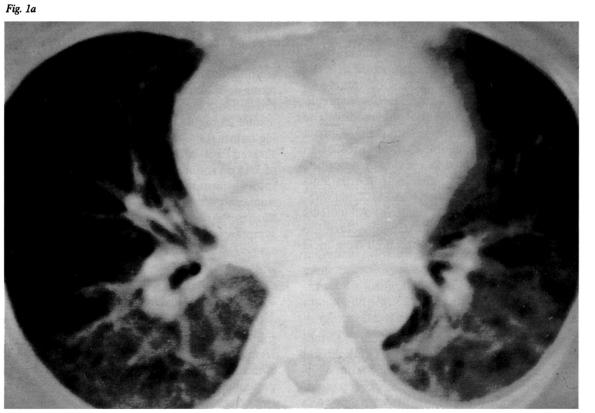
Chest radiograph showing diffuse alveolar and interstitial infiltrates, most prominent in the lower lobes (Figure 1A). Computed tomography scan showing heterogeneous ground glass opacities and septal lines (Figure 1B).
